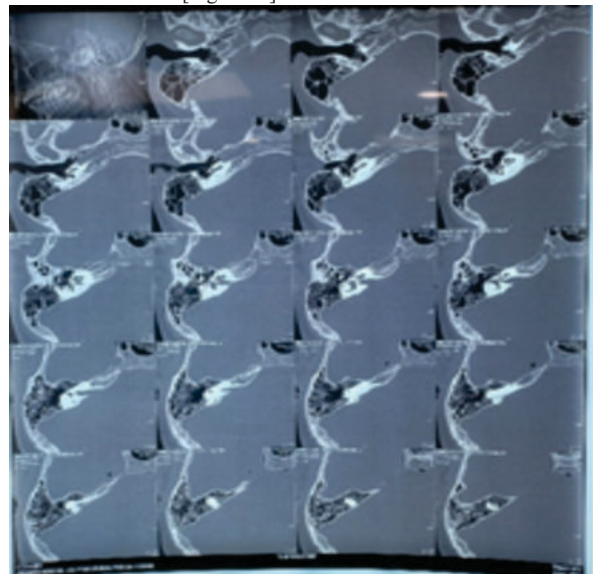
HRCT Of The Right Temporal Bone
